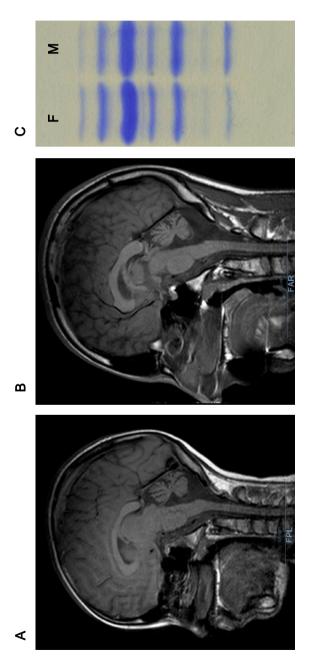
The brain MRI of a female patient (A) and a male patient (B) showing cerebellar atrophy, and Tf IEF of the same patients (C) showing type 1 profile with increased di- and asialotransferrin (F-female, M-male) in family 1.
